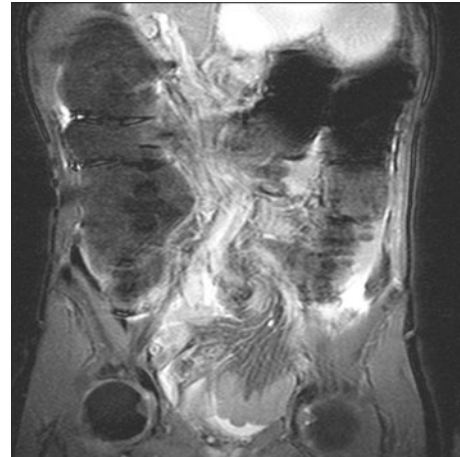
Coronal T2-weighted abdominal MRI image in sigmoid volvulus (dilated sigmoid colon with whirl pattern in mesentery)
